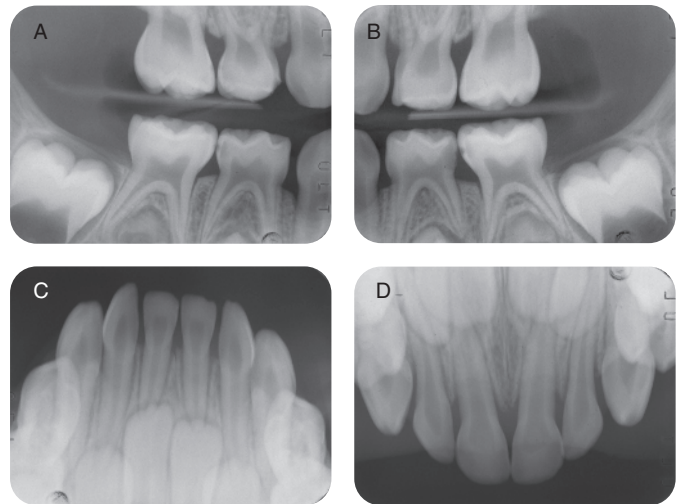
Pre-op intra-oral radiographs. A. Right bitewing radiograph, B. Left bitewing radiograph, C. mandibular occlusal radiograph, D. Maxillary occlusal radiograph
